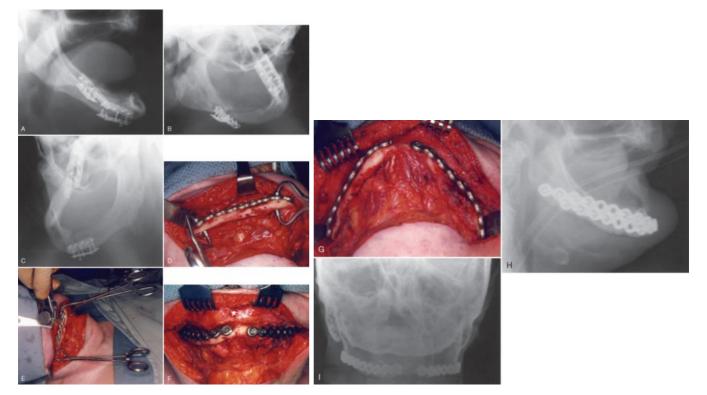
A 54-year-old institutionalized, mentally challenged man with spina bifida was referred for nonhealing and infection of bilateral edentulous body fractures. A, A lateral mandibular radiograph shows that the patient had previously undergone open reduction and internal fixation of the fractures and that miniplates had been applied to the lateral surface and the inferior border. The plates were fairly short in span and placed in an unfavorable compression zone, so during function the fractures with tend to gap superiorly. B, Right bolique view showing complete loss of fixation and osteolysis. C, Left oblique view demonstrating similar findings and screws backing out. D, The patient underwent wide extraoral exposure and debridement of the fibrous and granulation tissue on all bony margins. The right body fracture is seen reduced and a rigid reconstruction plate (2.3-mm system) was positioned and held with self-retaining clamps. E, A drill guide was used and locking screws inserted in the sound bone easist 4 to 5 mm away from the fracture site. F, Frontal view of the fully fixated mandible. G, Submental view. H, Postoperative lateral mandibular radiograph showing excellent projection and contours. I, Antergosterior radiograph demonstrating symmetry and normal contoursus.
